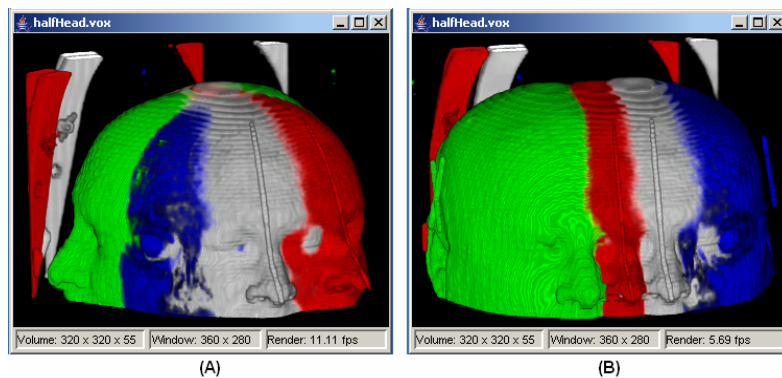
Demonstration of registration of 4 volumetric images: CT-1 (red), MR-T1 (green), MR-T2 (blue) and CT-2 (white). (A) rotation and (B) translation.
